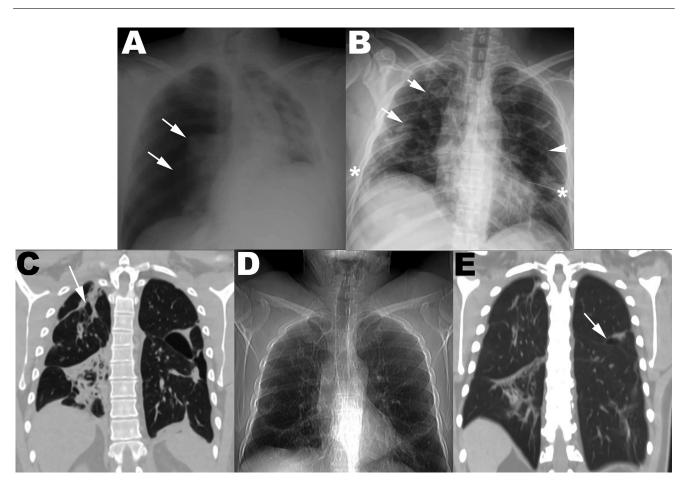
Findings of bilateral pneumothorax progression. (A) Simple anteroposterior thorax radiograph that shows the complete collapse of the right lung (arrows) and displacement of the mediastinal structures to the contralateral side is observed. (B) Simple posteroanterior thorax radiograph that shows the right chest drain accessing the fifth intercostal space and left chest drain in the sixth intercostal space (*). White arrows show the pulmonary parenchyma's line with evidence of pneumothorax on both sides. (C) Simple tomography of thorax with irregular interlobular septal thickening mainly in the right lung, the left lung with an intraparenchymal bulla in the posterior apical region around 6 \times 4 cm (white arrow). (D) Posteroanterior radiograph showing a pneumothorax resolution after removing both chest drains. E) Simple thorax tomography a month later, there are fibrotic scars in right pulmonary parenchyma, a bulla in the posterior apical segment of left lung decreasing to roughly 3 \times 2 cm (white arrow).
